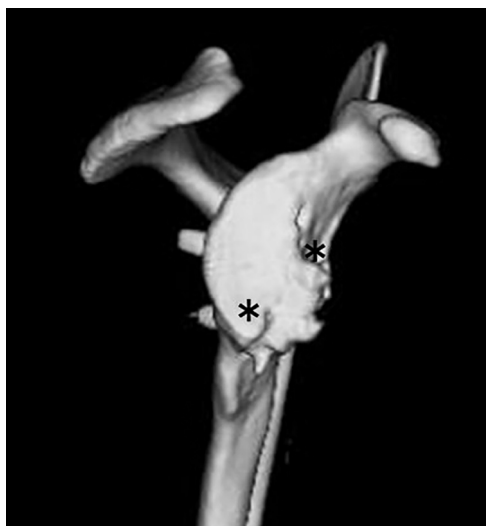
Postoperative 3-dimensional reconstructed computed tomography en face view of right glenoid shows the incorporated remodeled bone graft (bone loss, 11.4%). The asterisks mark the anchor holes for the Bankart repair.
